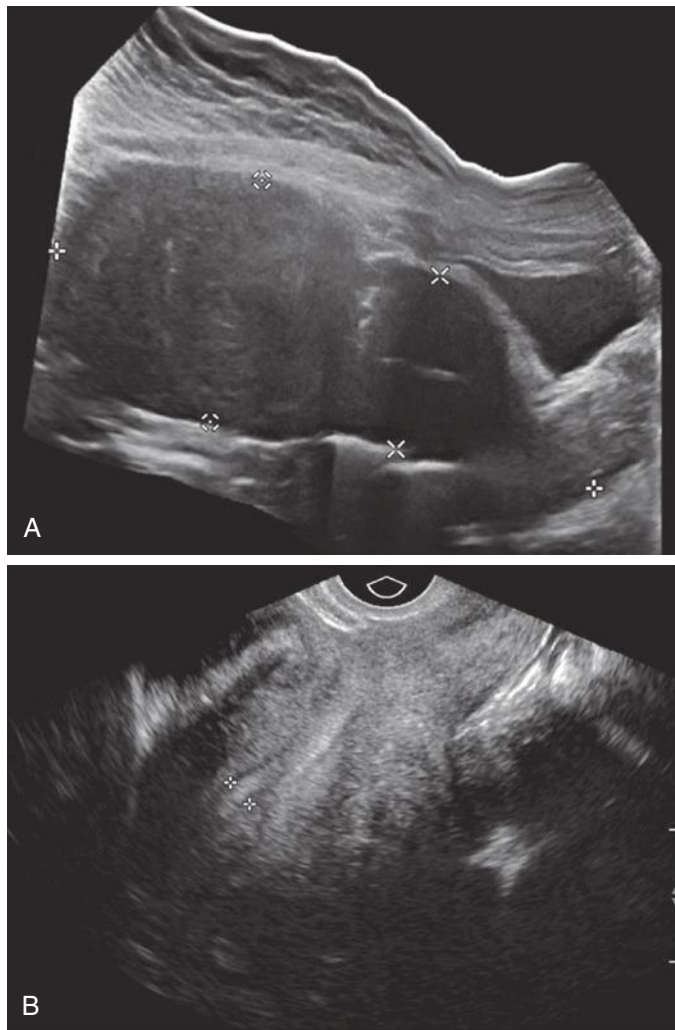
Pelvic mass only visible on transabdominal sonography. A, Longitudinal midline extended field of view transabdominal sonogram of the uterus demonstrates a large fundal leiomyoma (*calipers with central dot*) extending to the level of the umbilicus. Measurement of the uterus includes the large leiomyoma (*calipers*). B, Longitudinal transvaginal image does not image the leiomyoma, as it was located above the uterine fundus, beyond the field of view of the transvaginal probe. Calipers show endometrium.
